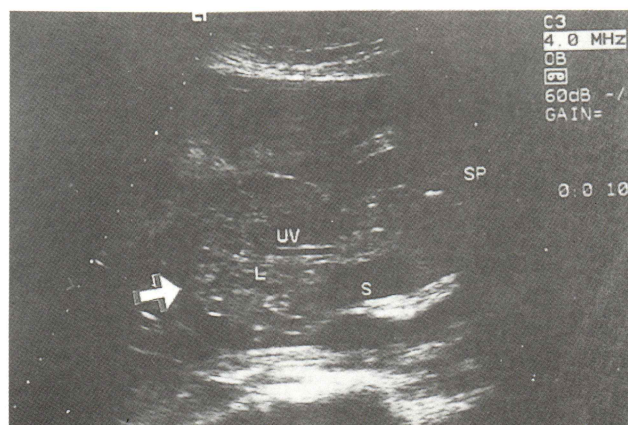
Ultrasound image of omphalocele.
